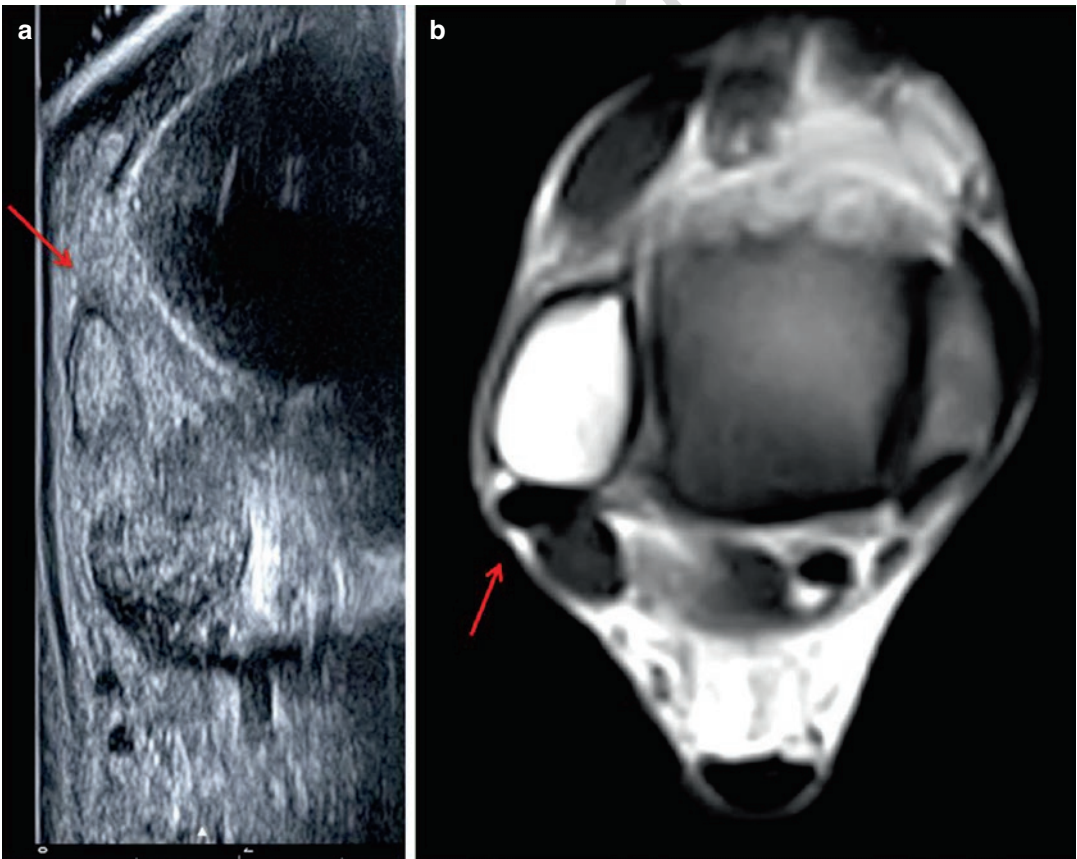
(a, b) Dynamic US and MRI scans: subluxation and tenosynovitis of the peroneal tendons due to a retinaculum tear secondary to inversion ankle sprain
